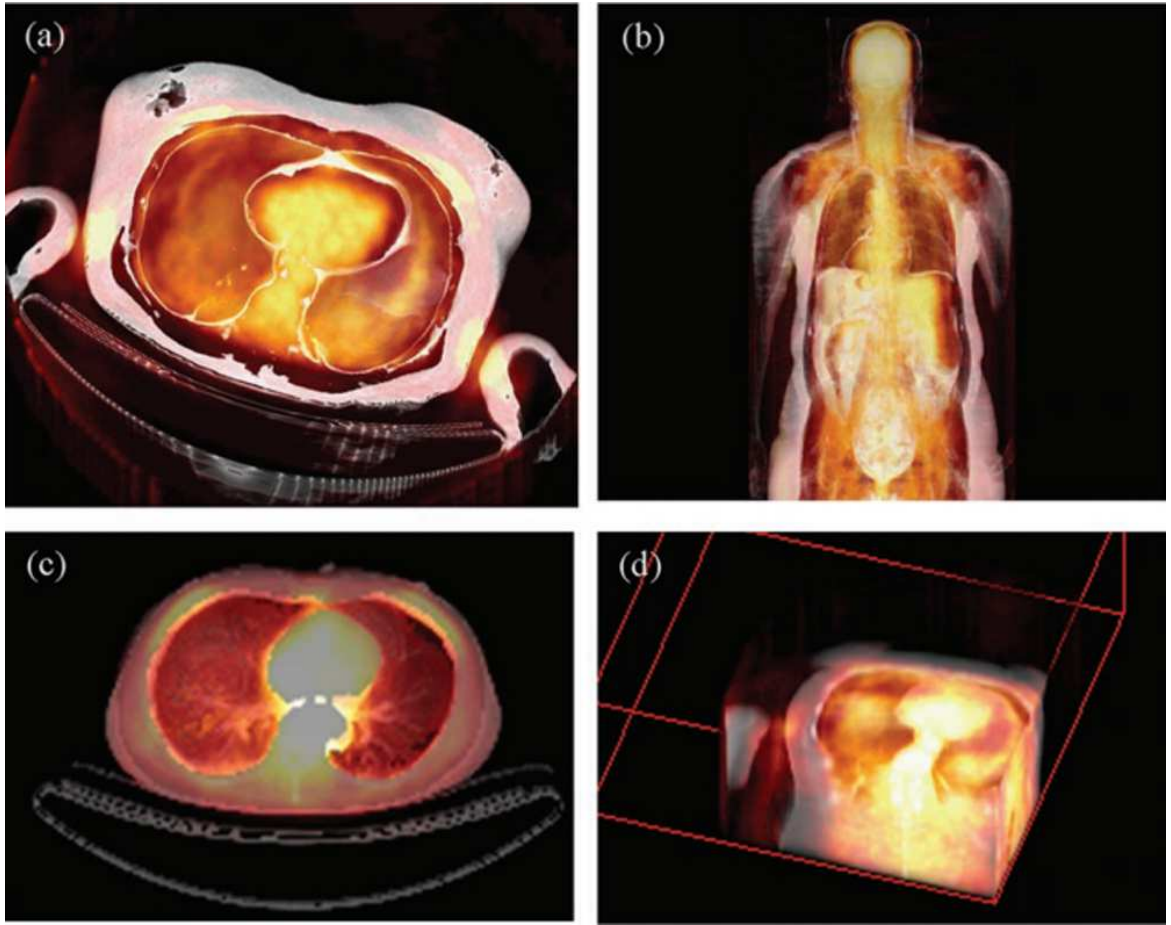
Direct volume rendering of PET-CT data, with segmentation being used to enhance the lung boundaries in A and C. Figure from: J. Kim et al. Real-Time Volume Rendering Visualization of Dual-Modality PET/CT Images With Interactive Fuzzy Thresholding Segmentation. IEEE Transactions on Information Technology in Biomedicine, 2007, 11, 161-169. © 2007 IEEE, used with permission.
